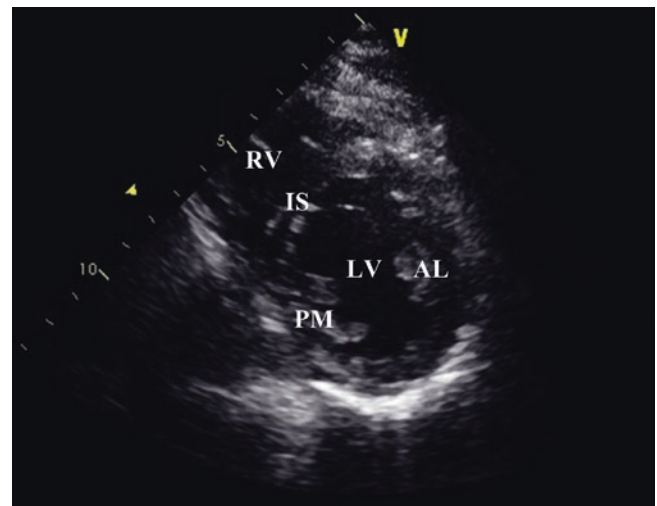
Parasternal short axis view at the level of the papillary muscles. Left ventricle (LV), interventricular septum (IS) and right ventricle (RV) are seen. The left ventricle appears round and symmetric. Anterolateral (AL) and posteromedial (PM) papillary muscles are the landmarks at this level. This view is useful for rough assessment of the left ventricular systolic function. See also Video 16.3
